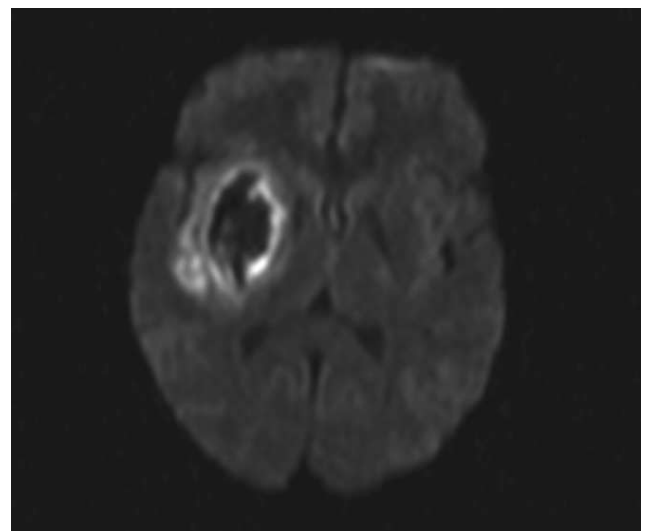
MRI-DWI – performed 24 h after stroke onset. Slight progression of infarct volume with haemorrhagic transformation of the infarction
